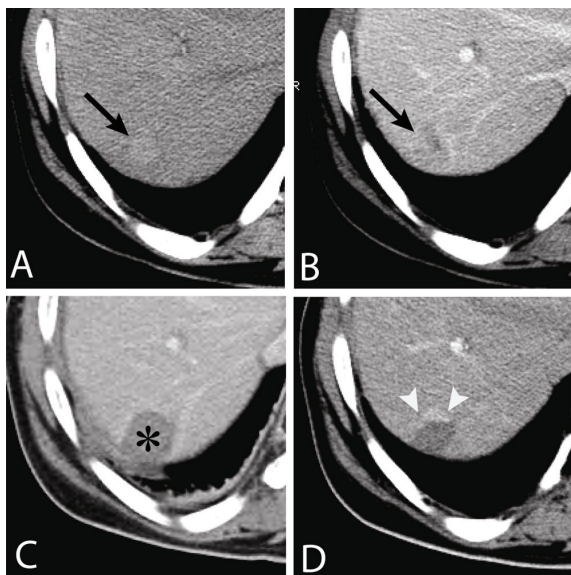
Recurrent tumor in a 51-year-old man treated HCC with radiofrequency ablation (RFA) alone. A, axial contrast-enhanced CT scan during arterial obtained before RFA shows an enhanced 1.8 cm HCC node (arrow) at postero-superior portion of right lobe of liver (segment VII). B, axial contrast-enhanced CT scan during portal venous phase of this nodule shows heterogeneous portal venous washout (arrow). C, axial contrast CT scan during portal venous phase obtained 1 hour after RFA shows complete ablation of tumor (asterisk) without residual tumor. D, follow-up 6 months of axial contrast-enhanced CT scan during early portal venous phase shows recurrent tumor at anterior rim (arrowheads) of the previous ablated area
